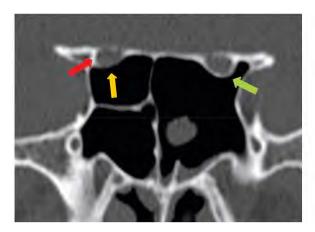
Coronal CT images showing type 2 op c nerve canal at the right (red arrow) with less than half of its canal circumference protruding into the sinus cavity. On the le, type 3 op c nerve canal with more than half of its canal circumference protruding into the sinus cavity (green arrow). Right canal bony dehiscence (orange arrow).
